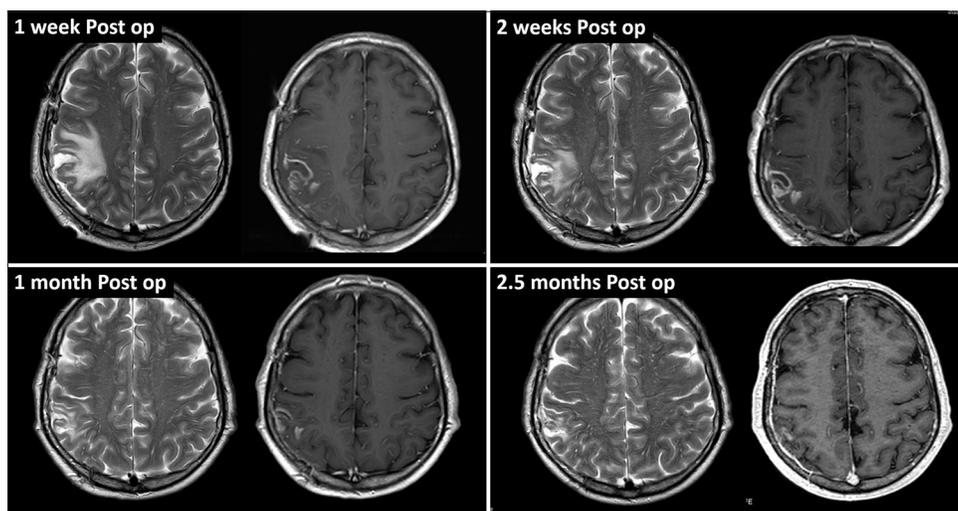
Postoperative magnetic resonance imaging (MRI) studies. Follow-up T2-weighted and gadolinium-enhanced T1-weighted MRI demonstrated progressive brain edema reduction, shrinkage of the residual cavity, and disappearance of contrast enhancement areas.
